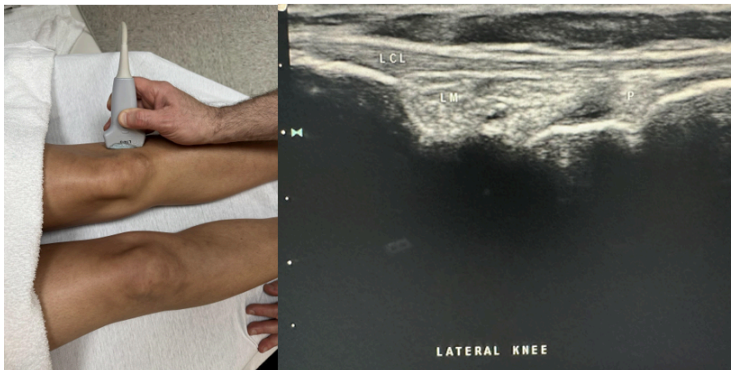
Side-by-side pictures of the transducer position and image of the lateral meniscus (LM), lateral collateral ligament (LCL), and popliteus (P). The abbreviations given here and labeled on the ultrasound image represent the corresponding structures.
